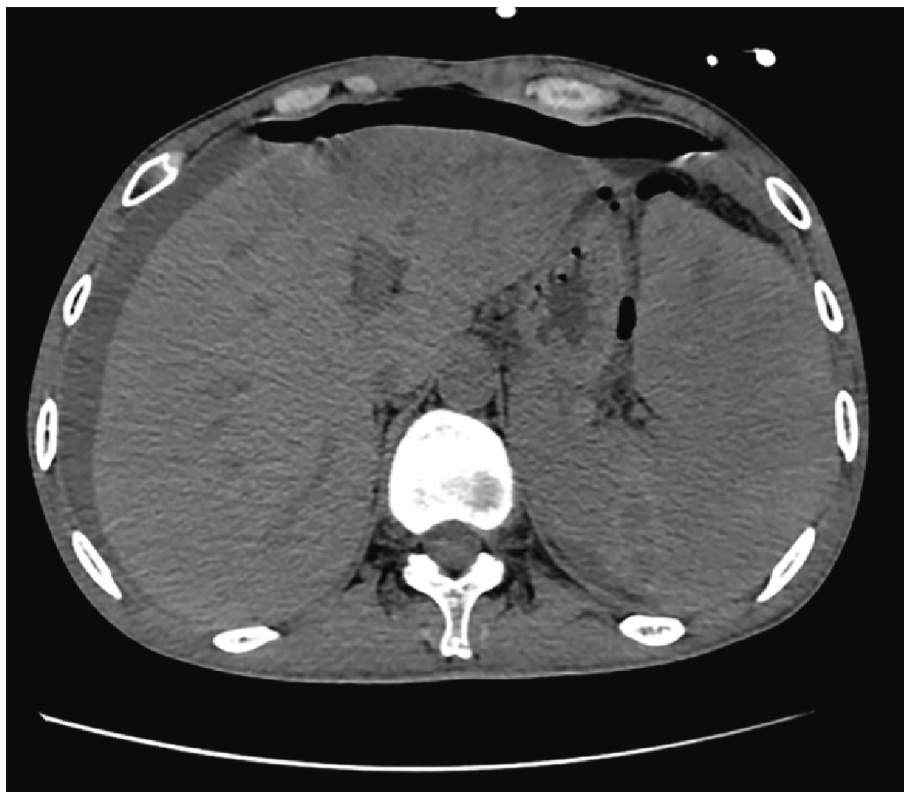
Enlarged spleen with visible hypodense areas (CT scan).
